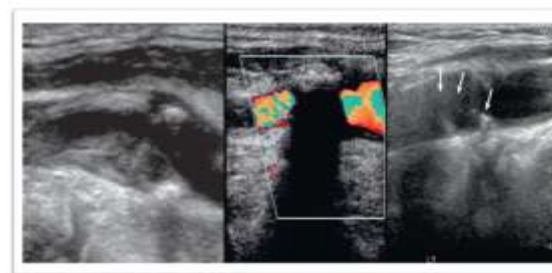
Grayscale and Doppler Images showing (From Left to Right) a) Homogeneous, b) Calcified and c) Heterogeneous plaques.
